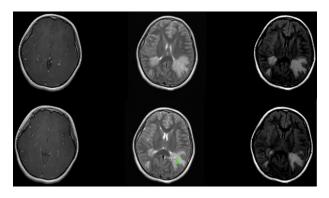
T1-weighted hypointense and T2-weighted hyperintense subcortical and sulcal lesions on the parietal lobe of both cerebral hemispheres. There was also significant vasogenic edema in the right fontal and bilateral parietal lobes.
